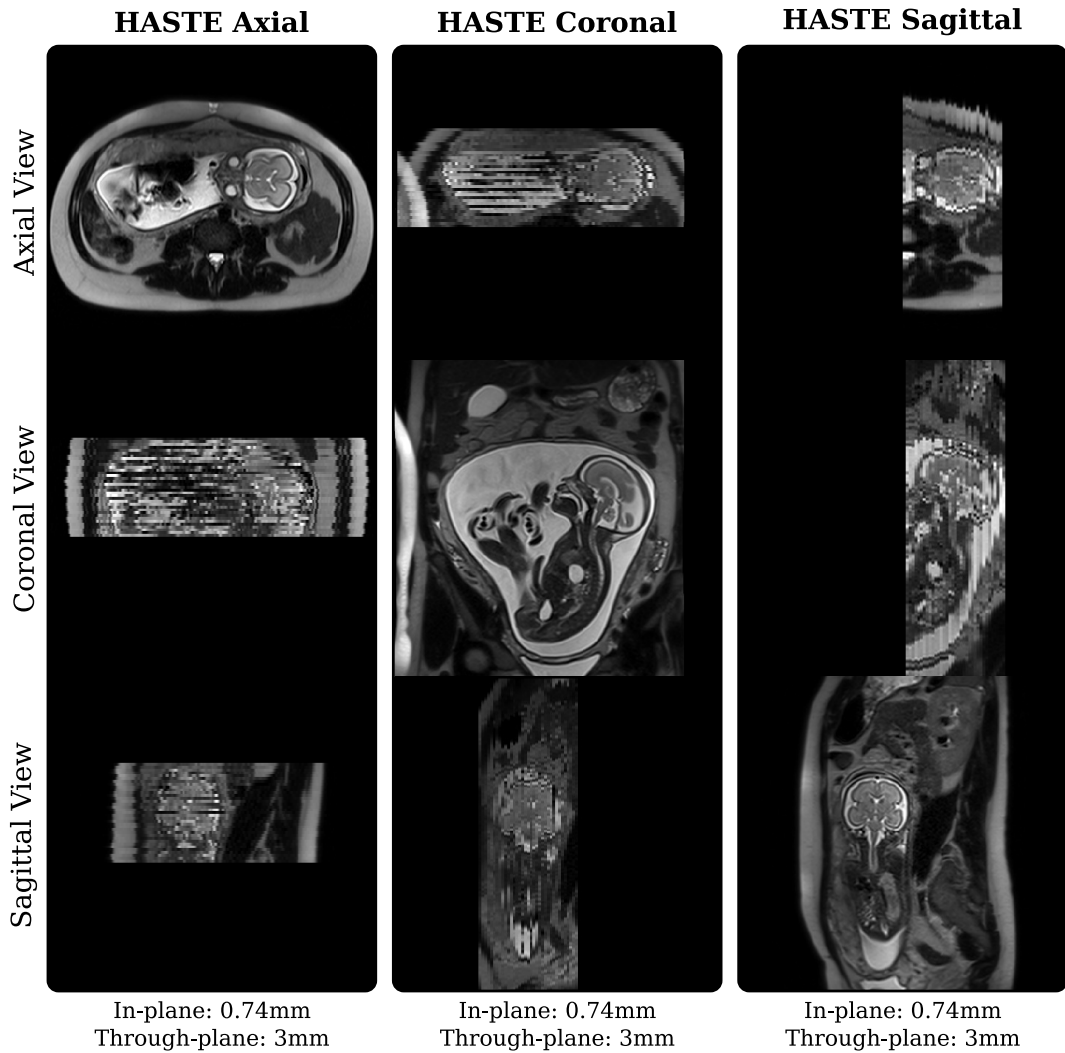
Visualization of typical fetal MRI data acquired at 1.5 T (Data courtesy of Prof. Jan Deprest, KU Leuven). An interleaved scanning protocol was deployed where each stack was acquired using three packages of temporarily sequential but spatially separated slices. Maternal and fetal motion is visible throughout the HASTE stacks. Axial and coronal stacks show the effect of magnetization transfer where some slices have suffered from reduced signal intensity. The coronal stack is affected by wrapping artefacts.
